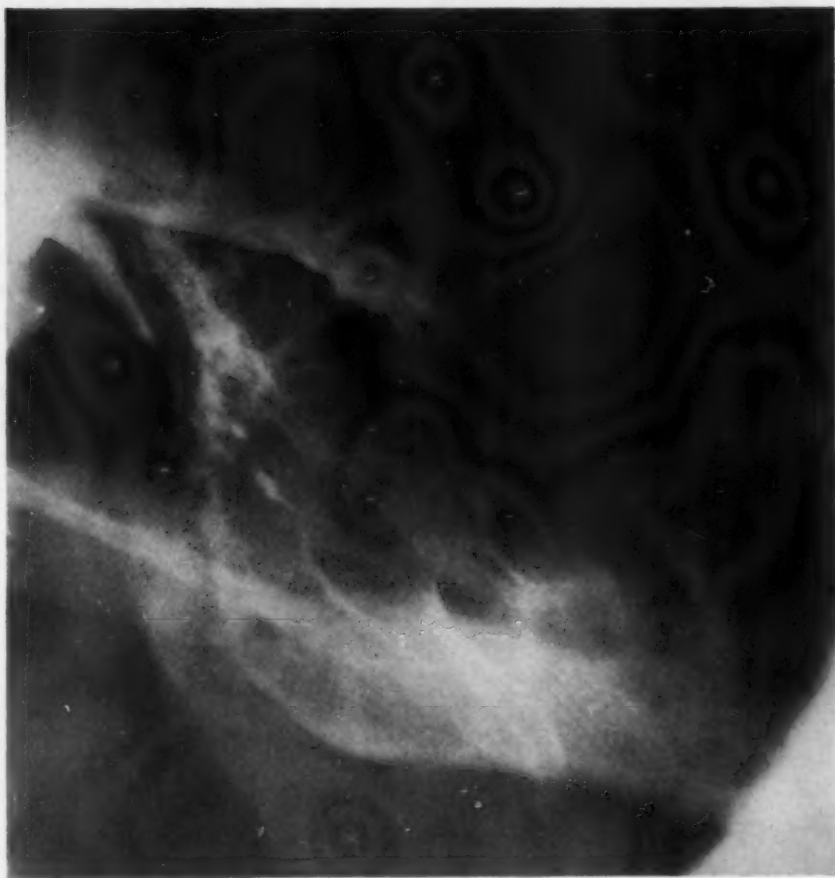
Case 3. Radiograph of ameloblastoma. This is the multilocular type. (Neg. 68185.)
